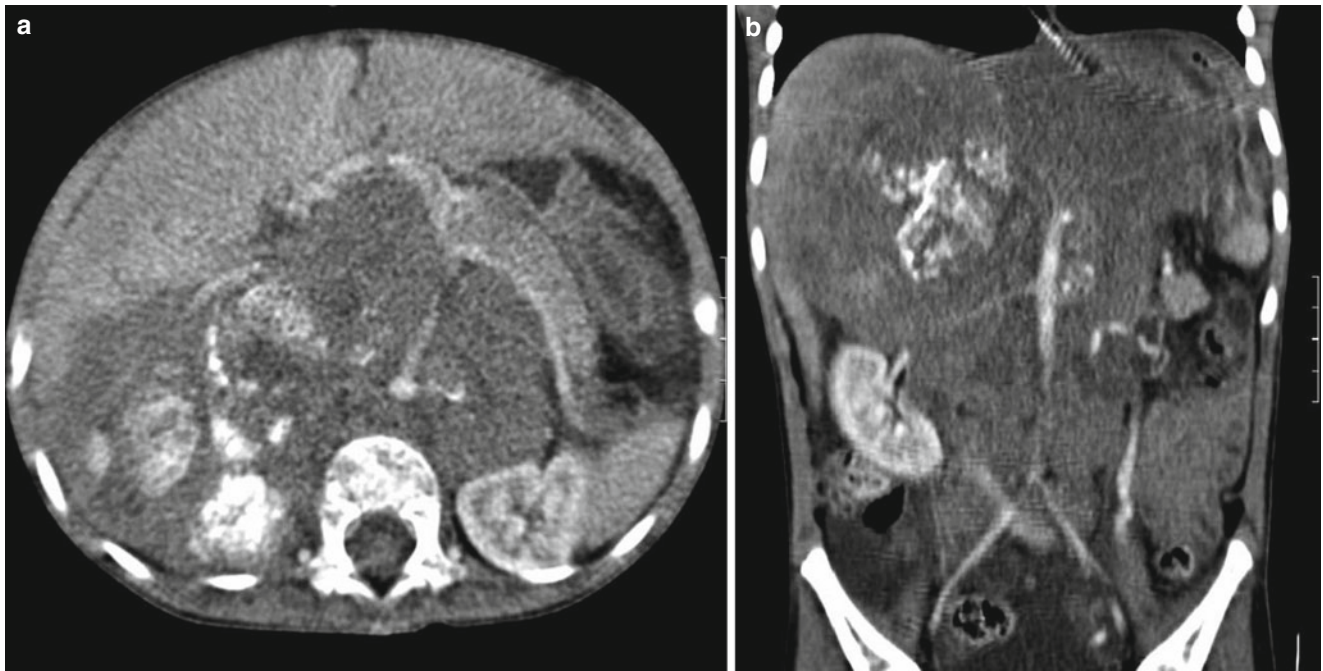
CT in an infant with neuroblastoma. (a) The tumor extends throughout the retroperitoneum and characteristically engulfs vessels and pushes them anteriorly. (b) Coronal reformats showing the tumor
